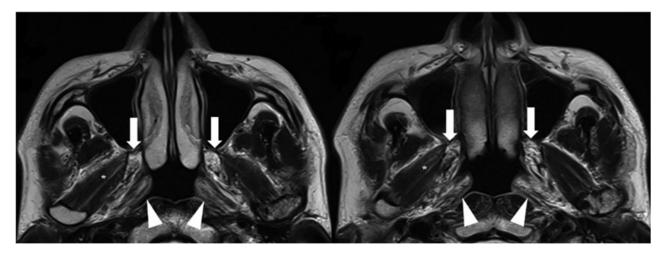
Axial, T2-weighted magnetic resonance images of the patient. Tensor veli palatini (arrows) and levator veli palatini (arrowheads) muscles appear whitish compared to the lateral pterygoid muscle (asterisks) due to fatty infiltration. The right tensor veli palatini and levator veli palatini muscles are relatively small compared to the left ones.
